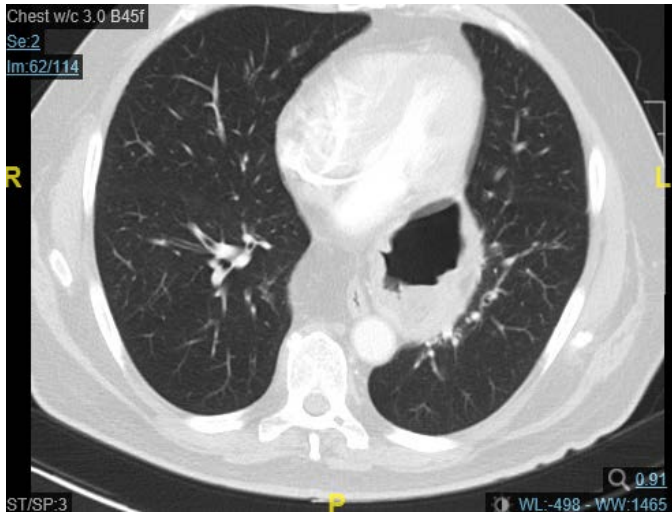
CT chest with contrast: large hiatal hernia containing most of the stomach; diffusely abnormal airways affecting all lobes
